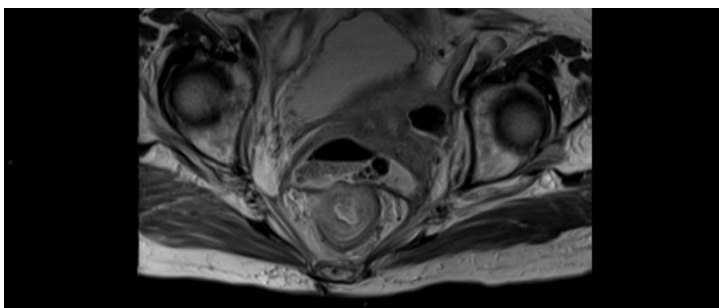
MRI appearance of an anastomosis fistula in the rectum. T2-weighted sequences. Voluminous abscess located anteriorly to the rectum, between it and the uterus, formed due to a fistula anastomosis.
